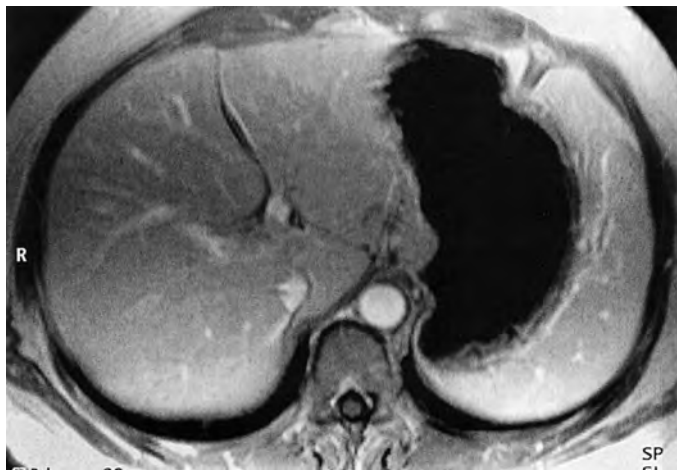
Liver MRI: T1-weighted gradient-echo image after administration of gadolinium. The aorta, IVC, and hepatic parenchyma are brightly enhanced. Gadolinium enhancement affords improved characterization of focal lesions.
